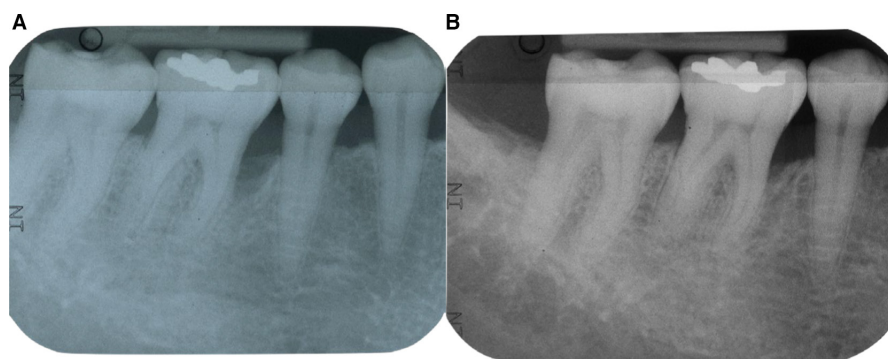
A, Radiographic scenario of an infrabony defect on the mesial aspect of tooth 46. B, Periapical radiograph at the 12-month follow-up examination following non-surgical mechanical instrumentation documenting radiographic bone fill.
